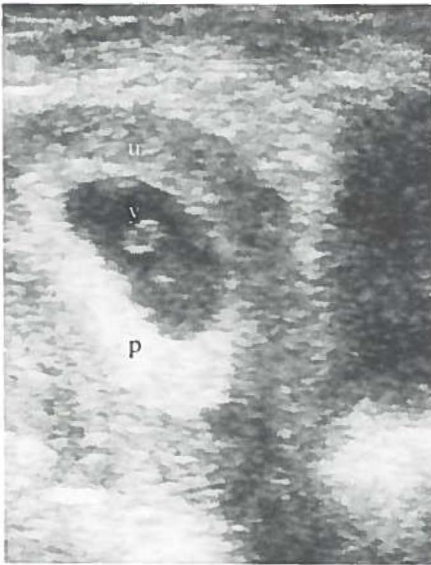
Longitudinal ultrasound scan at intake (7 weeks + 4 days gestation) showing anteverted uterus (u), posterior placenta (p) and yolk sac (y).
